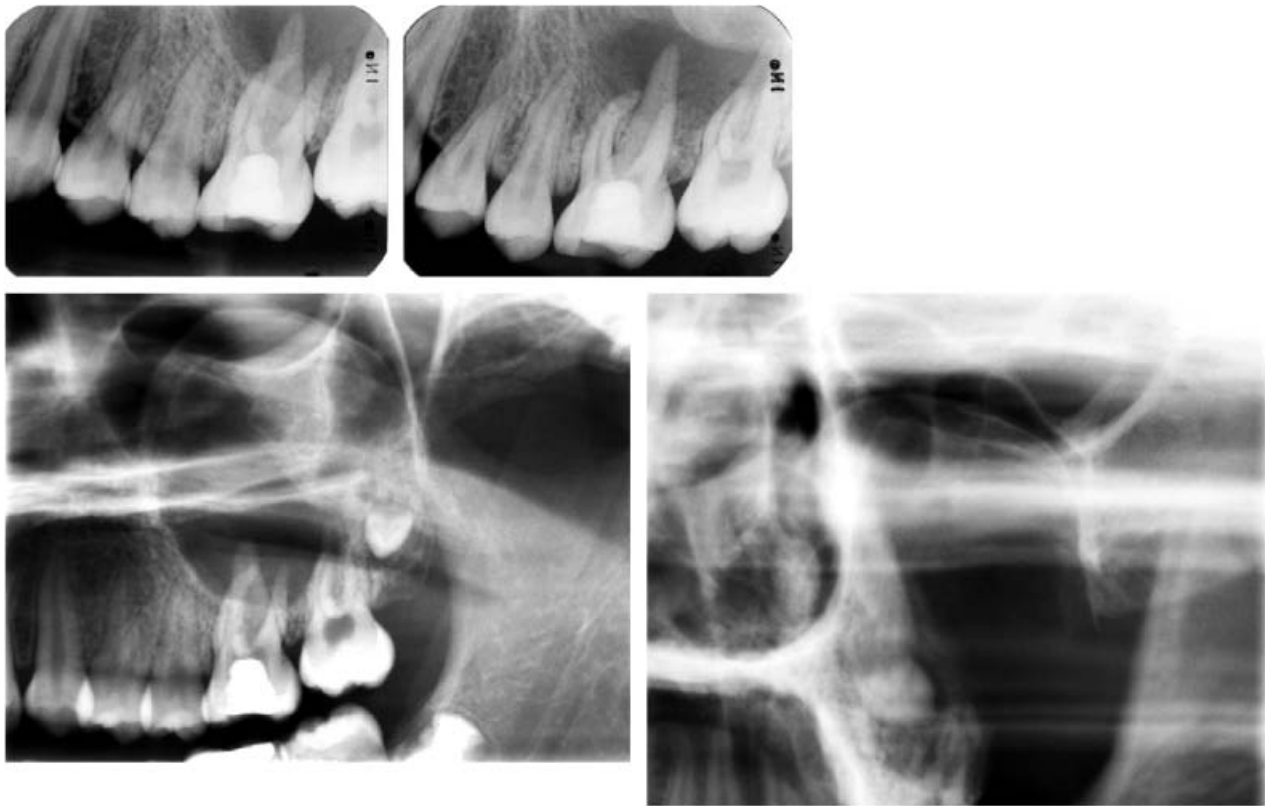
In this 12-year-old girl presenting with pain in the upper left molar region intraoral radiographs did not describe a suspected lesion in its entirety. The absence of a clear anterior and lower border of the maxillary sinus and the homogeneous density of the region of the sinus indicate the presence of an extensive lesion. A lateral sinus scanogram (left lower radiograph) and an anterior sinus scanogram (lower right radiograph) demonstrate the presence of a large cystic lesion that, as a result of being infected, had a lower lateral border that had become resorbed. Lower two radiographs were obtained with a Scanora multimodality unit (Soredex Co., Helsinki, Finland).
